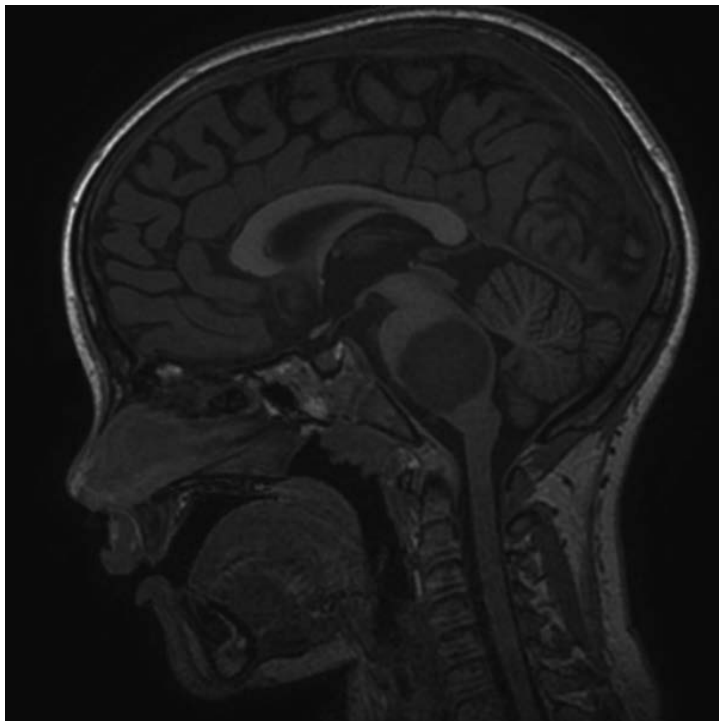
Precontrast sagittal volume T1 MRI of the brain of a DIPG patient showing diffusely infiltrating pontine mass.
